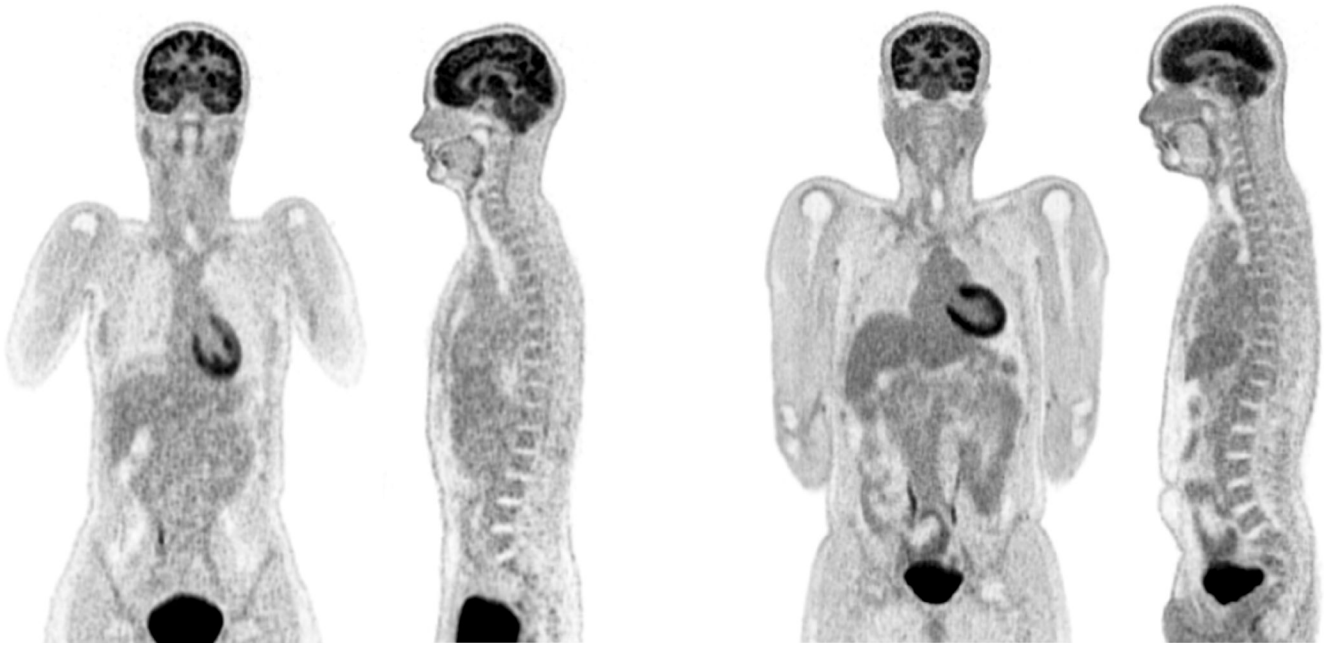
Example of images from a healthy female volunteer scanned on the total-body scanner with 15 MBq (0,5 mCi, sagittal and coronal images on the left) and a healthy male subject scanned with 74 MBq (2mCi, sagittal and coronal images on the right) ^{18}F -FDG (courtesy of Dr. Chaudhari).
